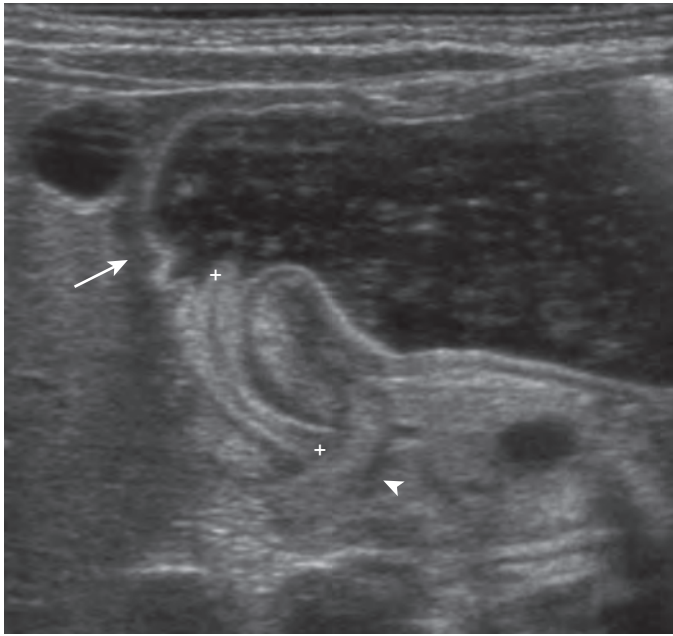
Pyloric stenosis: ultrasonography. Gastric outlet obstruction secondary to hypertrophied pyloric muscle. The stomach is distended with fluid given orally. The pyloric channel (between calipers) is abnormally elongated to more than 17 mm and does not open to allow passage of fluid. Reliable sonographic landmarks demarcating the beginning and end of the pylorus are the fluid-filled gastric antrum (arrow) and the echogenic, triangular duodenal bulb (arrowhead), respectively.
